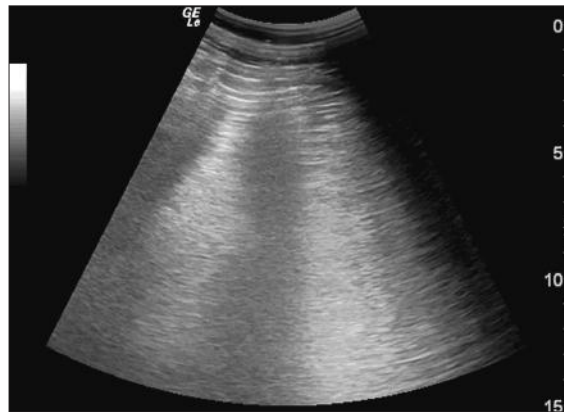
Curvilinear transducer that shows no transmission of the ultrasound wave until gel is applied to the transducer face. [View E-book for ultrasound clip or watch it at <http://goo.gl/ZadCSC>.](#)
